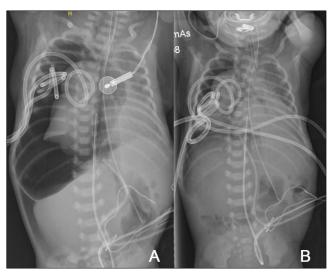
Chest and abdominal radiographs showing right-sided pneumothorax, pneumomediastinum, and pneumoperitoneum (massive air leak) – before (A) and after (B) drain 4
